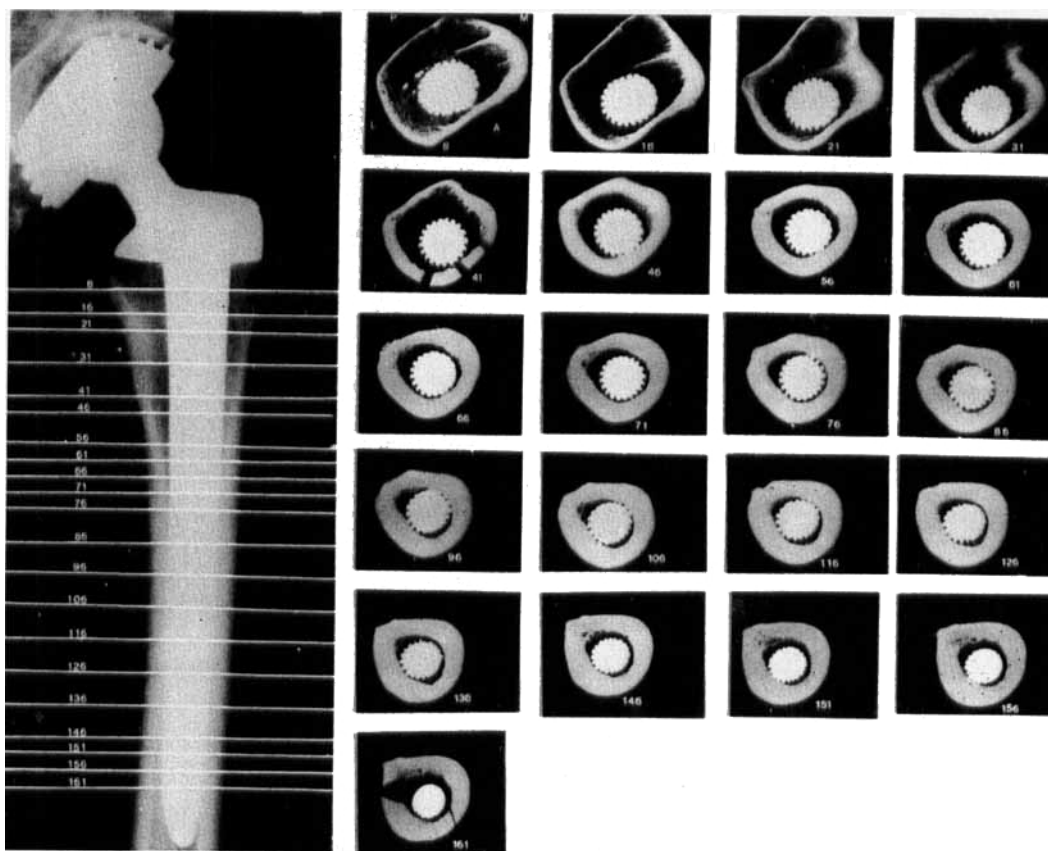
Frontal radiograph of the left femur with 21 contact radiographs of the cross sections. A = anterior, M = medial, P = posterior, L = lateral.
